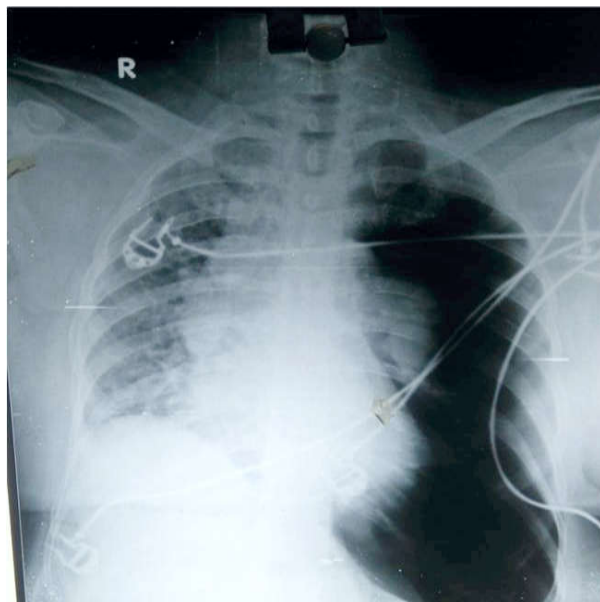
Chest radiograph showing pneumothorax on the left side with mediastinal shift to the right
